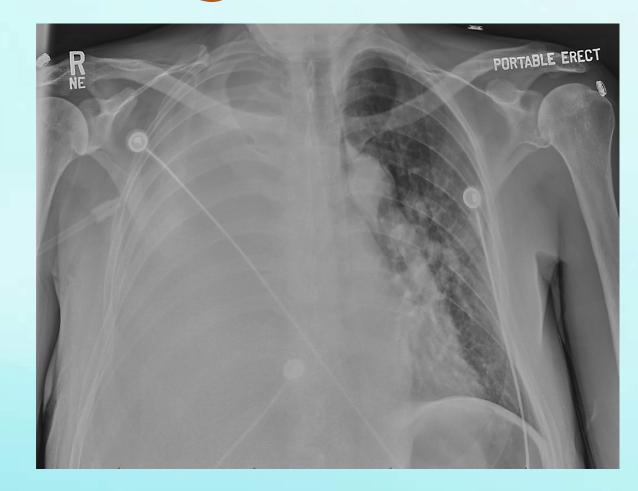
Chest x-ray demonstrating complete opacification of the right hemithorax with tracheal deviation to the left.
